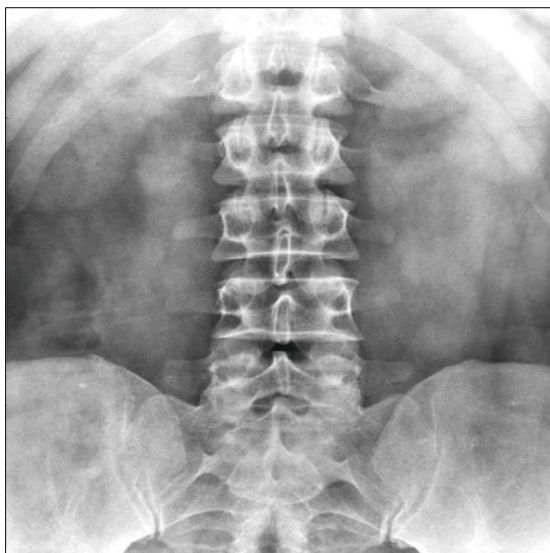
Plain Xray of the Abdomen
